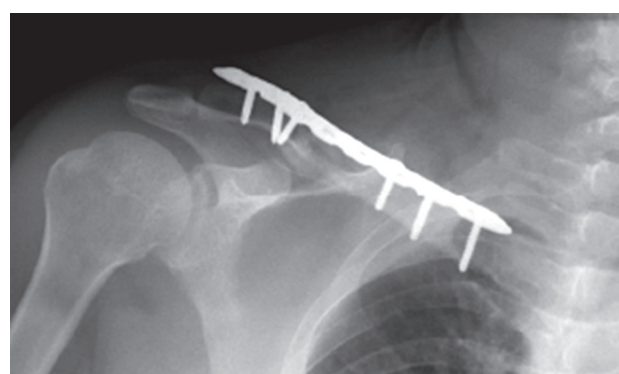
Postoperative x-ray in AP to monitor healing.
